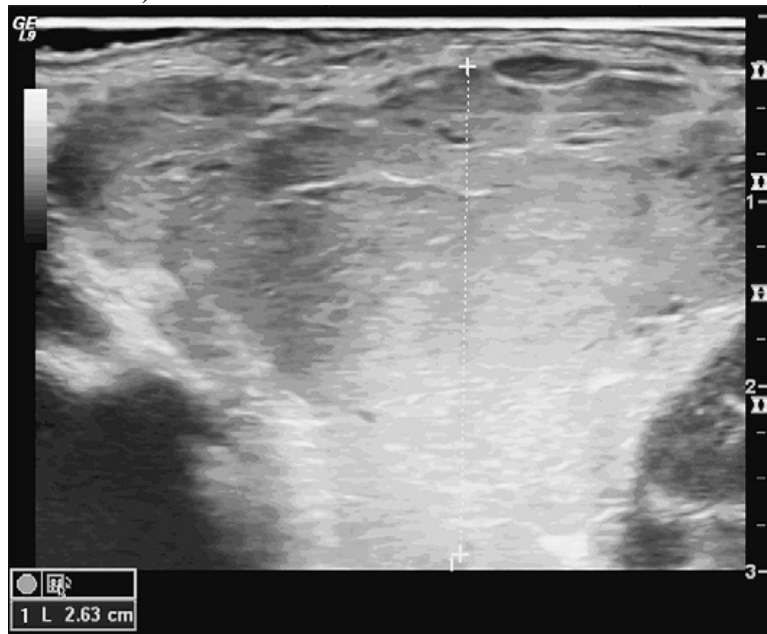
Transverse sonogram of right parotid gland of a 6-month-old baby. Big lobulated hypoechoic lesion inside the gland indicative of hemangioma. (Philips Katz et al.)
